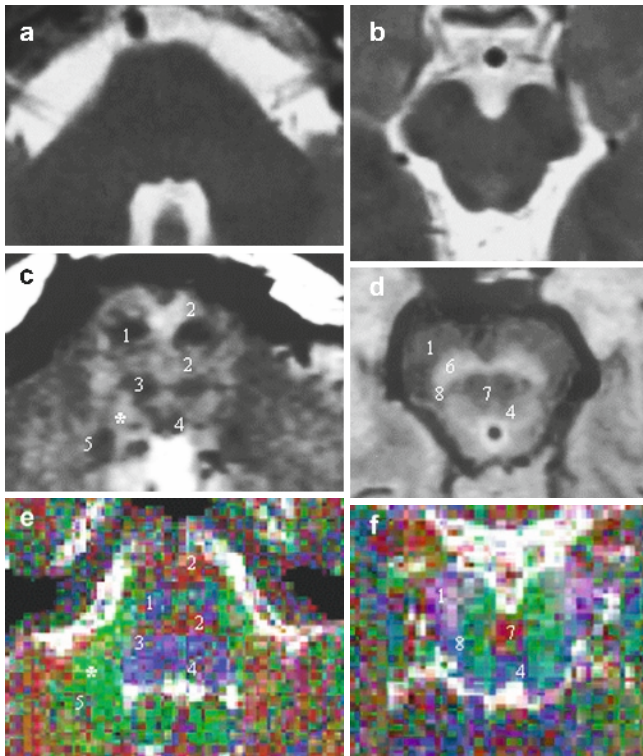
Normal MRI anatomy of brainstem pathways. T2 weighting (a, b), proton density weighting (b, e, f) color coded DTI maps (c, f). Axial sections through the lower part of the pons (a, c, e) and the midbrain (b, d, f). 1 Pontine base with corticospinal tract (pyramidal pathway) and 2 pontocerebellar tract (middle cerebellar peduncle), 3 pontine tegmentum with tegmental tract, 4 medial longitudinal fascicle, 5 spinocerebellar tract (lower cerebellar peduncle), asterisk: lateral part of the reticular formation with vestibular nuclei, 6 substantia nigra, 7 crossing of cerebellar efferents (cerebellorubrothalamic tract), 8 medial lemniscus, color coding on DTI color maps, red: trajectories in right-left direction, green: trajectories in AP direction, blue: ascending and descending trajectories
